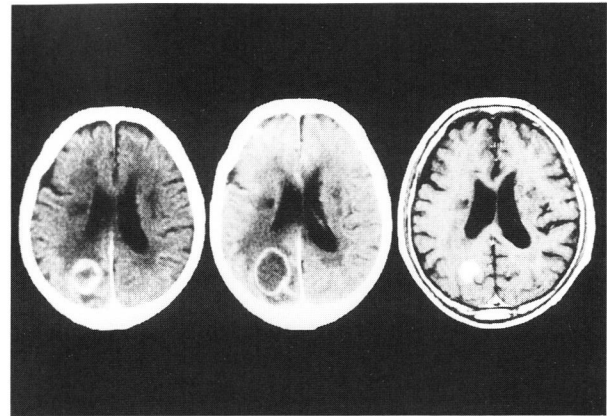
Serial contrast CT and MRI of 71 years-old-man who developed left parietal sign. A. Left parietal mass from lung squamous cell carcinoma with perifocal edema was recognized. B. In one week after gamma knife surgery, this patient developed minimal right hemiparesis with expansion of tumor. C. This patient recovered from this sign in a few days after administration of steroids. The MRI showed that the tumor was decreased in size in one month.
